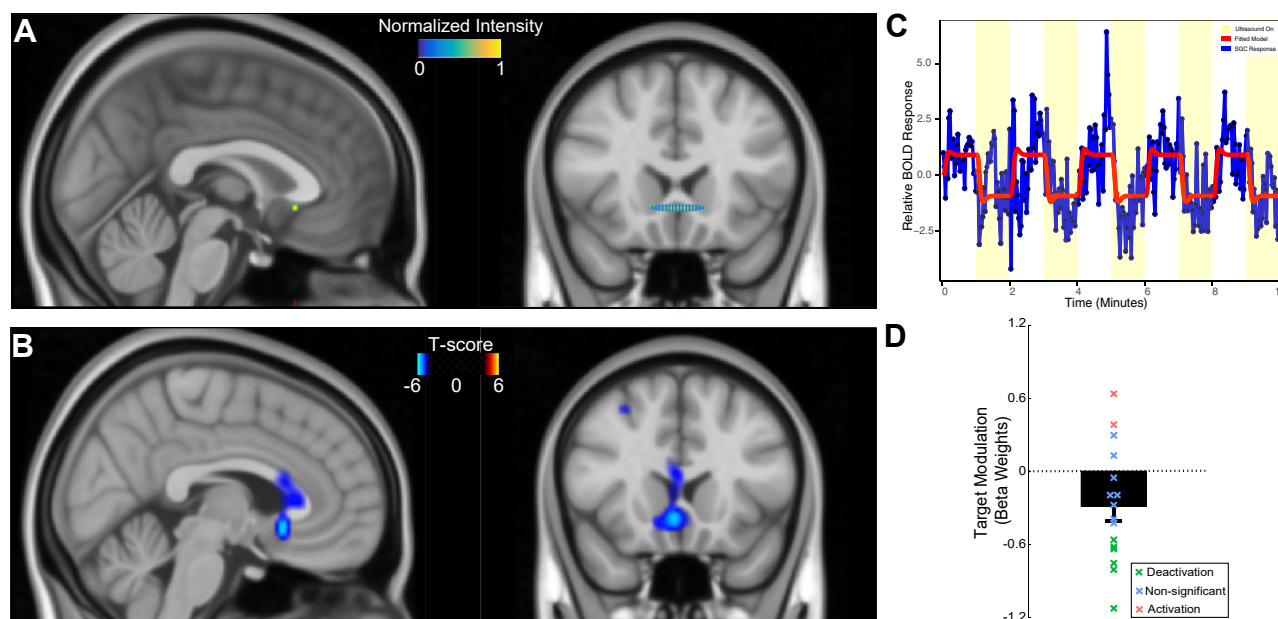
Ultrasonic targeting and neuromodulation. (A) Calculated ultrasound field produced at focus overlaid on sagittal and coronal images. The dimensions of the focus are $20.4 \times 2.4 \times 3.6$ mm (Montreal Neurological Institute space). (B) Target engagement in an individual participant, assessed using concurrent blood oxygen level–dependent (BOLD) imaging. The subcallosal cingulate cortex (SCC) was selectively deactivated: peak coordinates = (4, 20, –6), SCC small volume–corrected $p < .001$ and whole-brain familywise error–corrected $p < .001$. Display thresholds: $|t| > 4$, cluster size > 50 voxels. (C) SCC BOLD response from the example participant in (B) (blue) and fitted block-design model (red) are shown. BOLD signal decreased with ultrasound delivery (yellow). (D) Modulation of the targeted SCC region across the cohort ($n = 16$). Each symbol represents the BOLD response extracted from the SCC for an individual participant. The bar shows the mean \pm SEM response: $t_{15} = -2.43$, $p = .028$, 1-sample 2-tailed t test. The symbol colors indicate individual participant results from small-volume correction analyses (see Table S2). Statistically significant deactivation was observed at the individual participant level in 5 participants, and 1 participant trended toward deactivation (green). Two participants showed a significant activation (red). In 8 participants (blue), the modulation was not significant at the individual level. SGC, subgenual cingulate gyrus.
